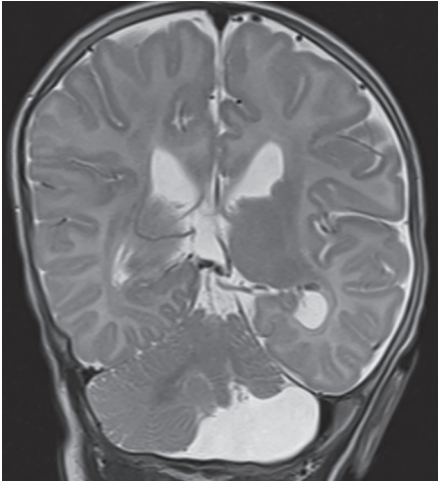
A T2-weighted MRI showing posthemorrhagic cerebellar hypoplasia
